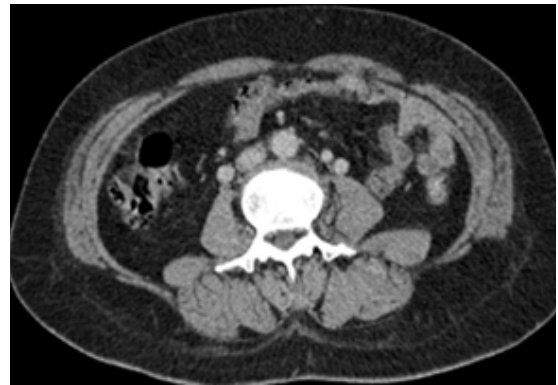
After a week, follow up CT scan shows patent IVC without residual thrombosis.
